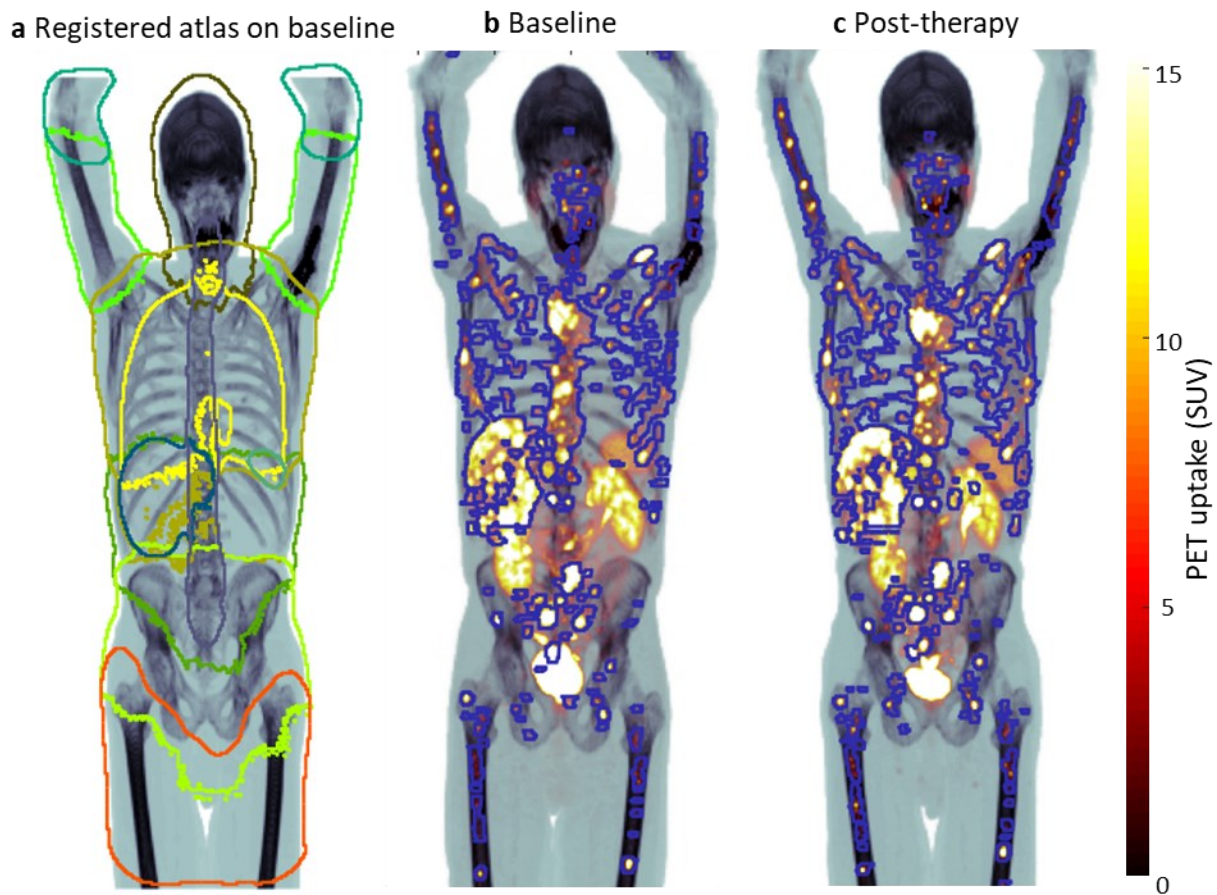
Example patient: a 73-year-old male presenting with 162 unique lesion tracks. This patient progressed 18 months after the 1st cycle of PRRT. The images are a) a maximum intensity projection (MIP) of the CT and the body-part segmentation atlas, b) along with a MIP of the PET/CT fusion with the lesion mask superimposed for the baseline PET/CT acquisition and c) for the post-therapy acquisition.
